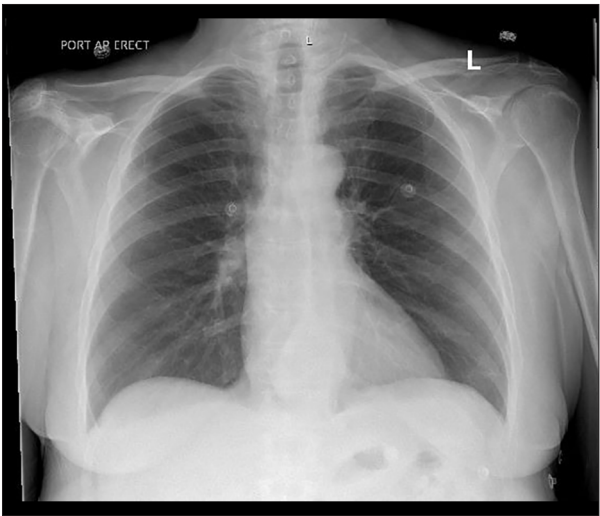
Chest radiograph. Chest X-ray demonstrating no acute cardiopulmonary abnormalities.
